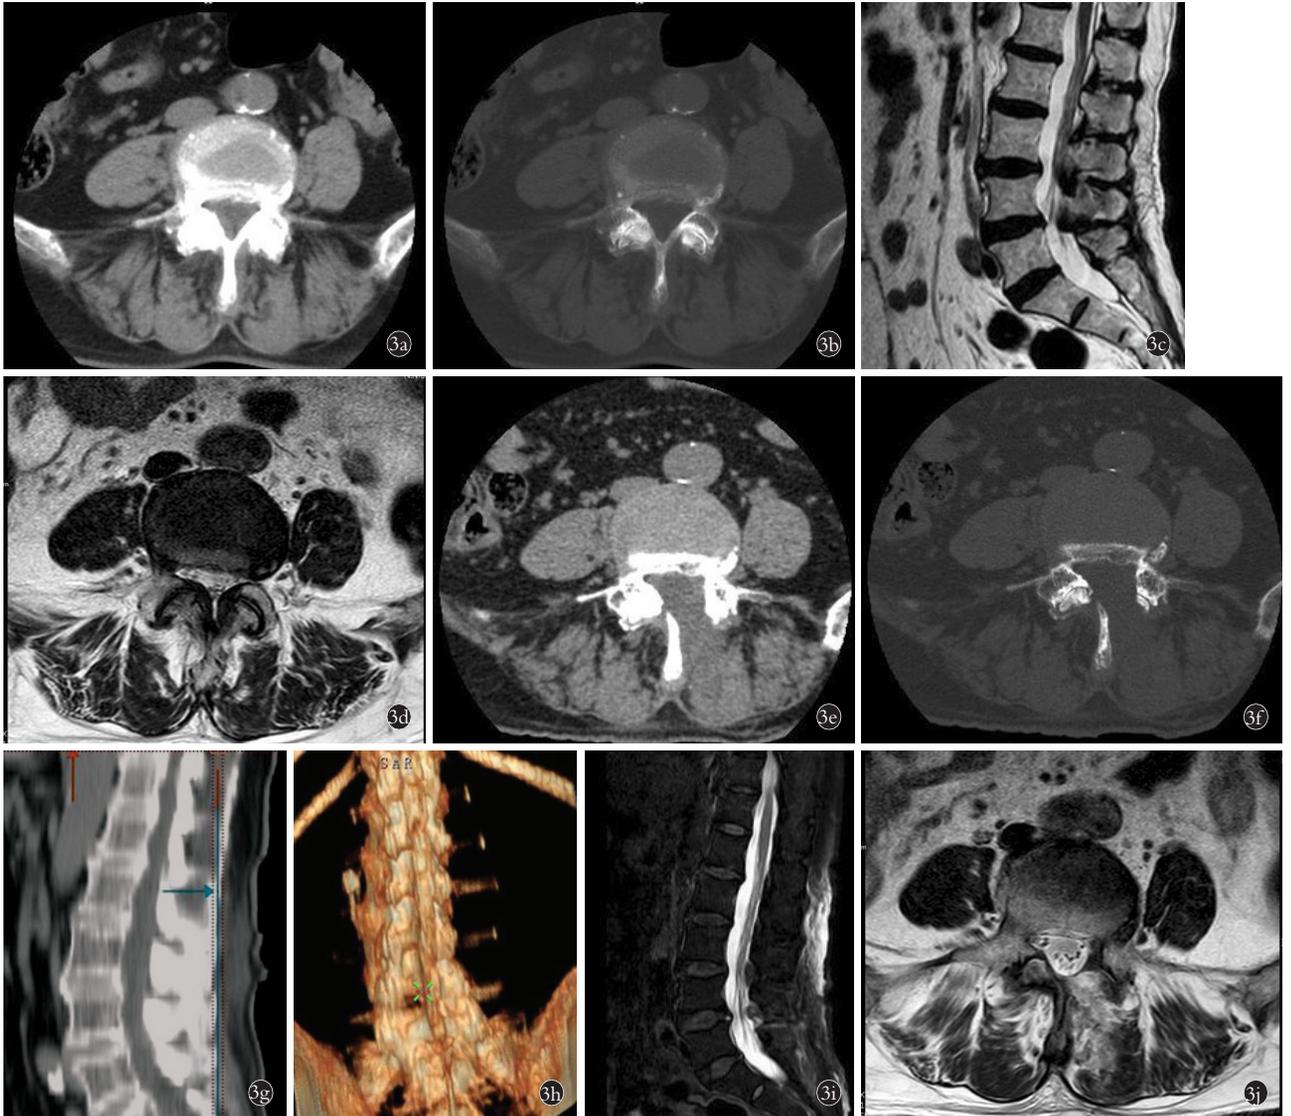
患者,女,79岁,L_{4,5}腰椎管狭窄症 3a,3b. 术前 CT 软组织窗及骨窗示 L_{4,5} 节段椎管狭窄 3c,3d. 术前 MRI T2 像示 L_{4,5} 水平椎管狭窄并硬膜囊受压 3e,3f. 术后 3 d CT 软组织窗及骨窗示双侧狭窄椎管减压充分 3g,3h. 术后 3 d, 三维重建示椎管减压充分, 关节突关节完整 3i,3j. 术后 3 d, MRI 示硬膜囊及神经根减压充分
